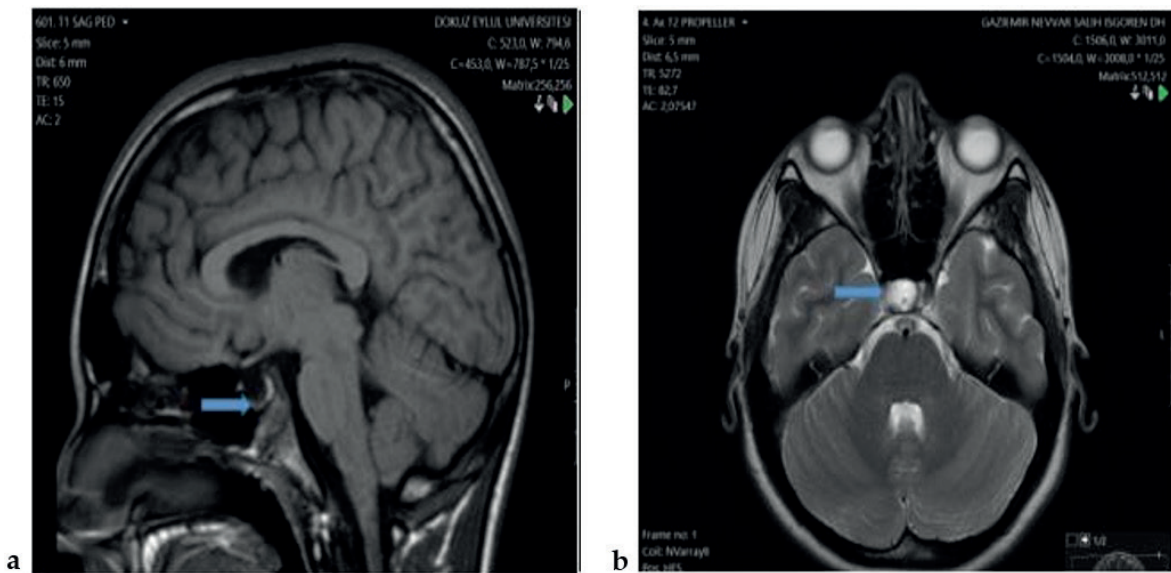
MRI brain scans of patient number 7. a. Midsagittal T1-weighted image through the sellar region shows decreased pituitary gland (arrow) height. b. T2-weighted axial image shows the increased signal intensity (arrow) of the CSF at sella turcica.
